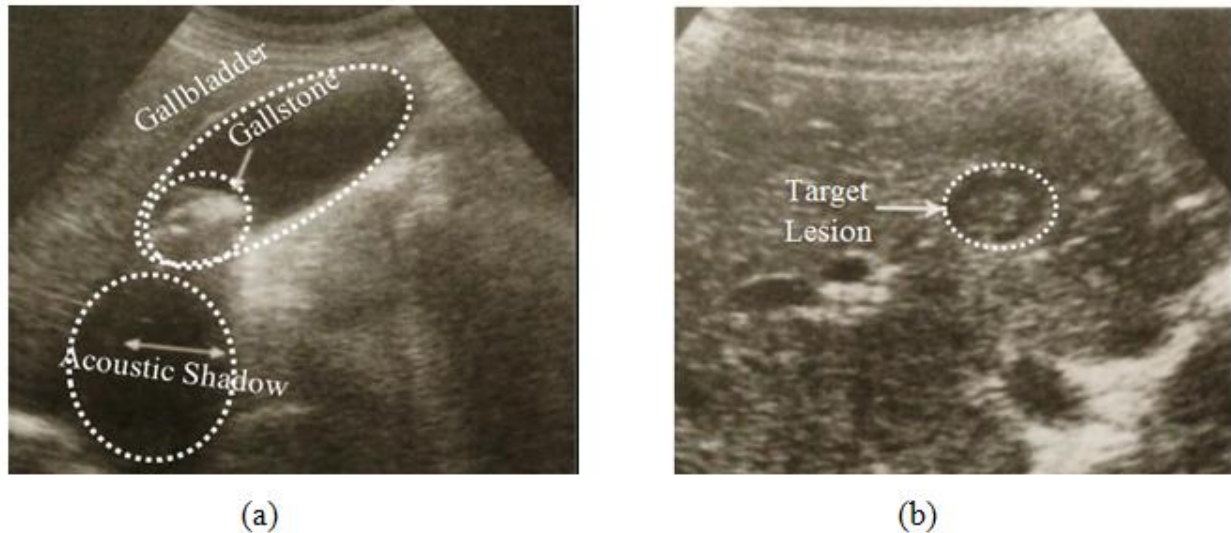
Ultrasound imaging performed on volunteers, a) gallbladder and gallstone b) patient's liver metastasis
